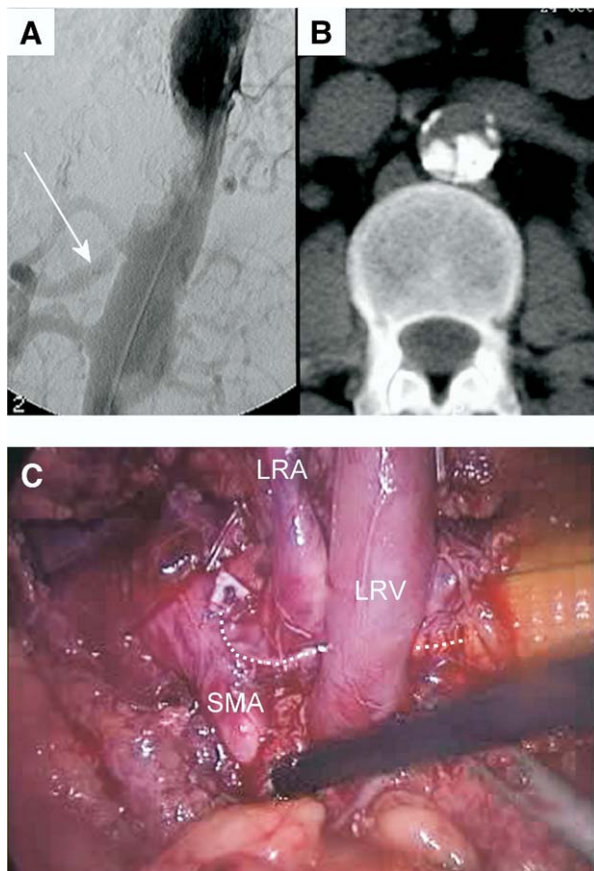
Preoperative lateral aortogram (*arrow*, celiac trunk) (A) and contrast-enhanced computed tomographic scan (B) showing partial luminal filling with the calcified material. (C) Intraoperative view after coral reef removal showing the suprarenal aortic suture and infrarenal graft implantation. *Dotted line*, Suture line of the suprarenal aortotomy; *SMA*, superior mesenteric artery; *LRA*, left renal artery; *LRV*, left renal vein.
